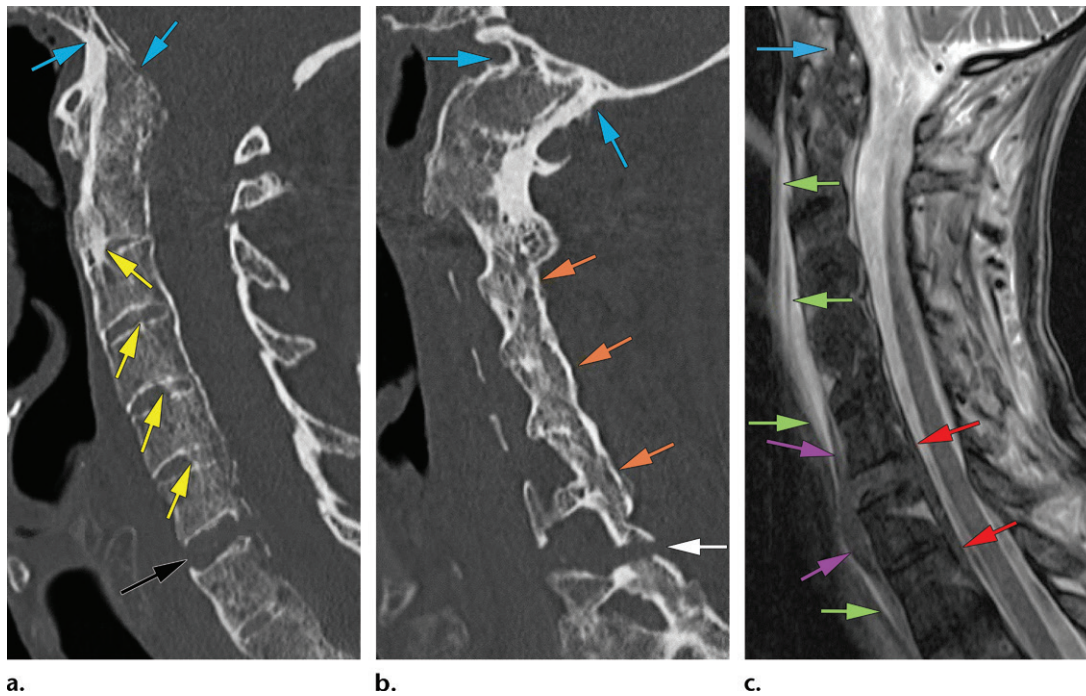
Hyperextension fracture in an 86-year-old man with AS who fell in his bathroom and presented with neck pain. (a) Sagittal spine reformatted CT image shows a hyperextension fracture (black arrow) at the C6-7 disk. Atlanto-occipital ankylosis (blue arrows) is also depicted, also known as craniocervical ankylosis, which can occur in patients with AS. Another characteristic feature of AS is the bridging syndesmophytes (yellow arrows), which cause ankylosis of the vertebral bodies. (b) Sagittal spine reformatted CT image shows the fracture (white arrow) extending through the posterior elements in the left C6-C7 ankylosed facet joint. There is diffuse ankylosis of the facet joints (orange arrows) and atlanto-occipital ankylosis (blue arrows). (c) Sagittal T2-weighted MR image shows extensive prevertebral soft-tissue edema (green arrows) and disruption of the ALL, with a hematoma anterior to C6 and C7 (purple arrows). Note the disruption of the posterior longitudinal ligament, with a ventral epidural hematoma extending from C6 to C7 (red arrows), and the atlanto-occipital ankylosis (blue arrow).
